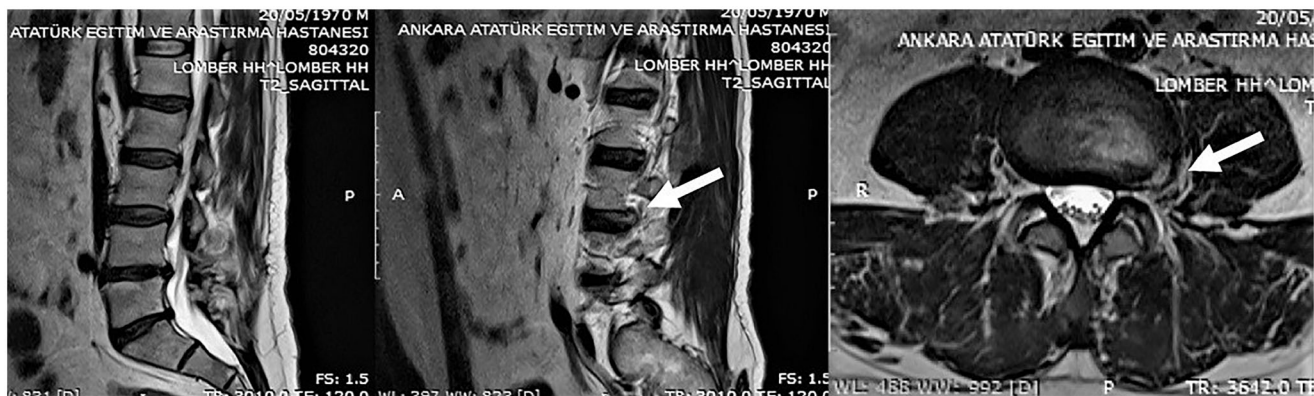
Preoperative MRI showing left L3-4 far lateral disc herniation and mostly left-sided broad-based L4-5 protrusion.
